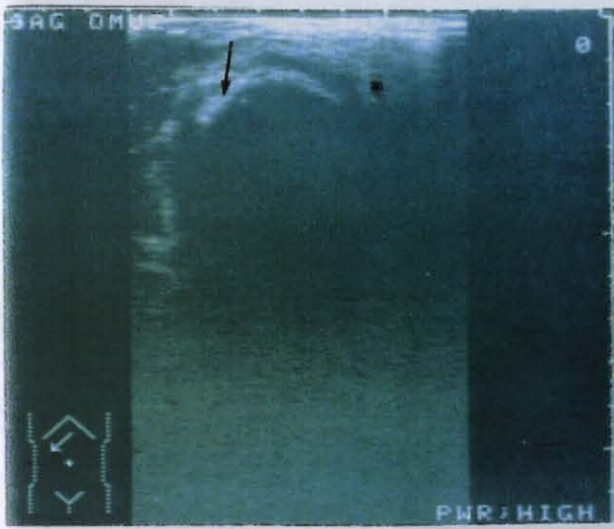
30 years patient with a chronic hematoma on the anterior part of the knee after a trauma. With the ultrasound examination an organized hematoma is imaged on the suprapatellar region (anterior part of the quadriceps tendons). 7.5 MHz linear transducer is used.
